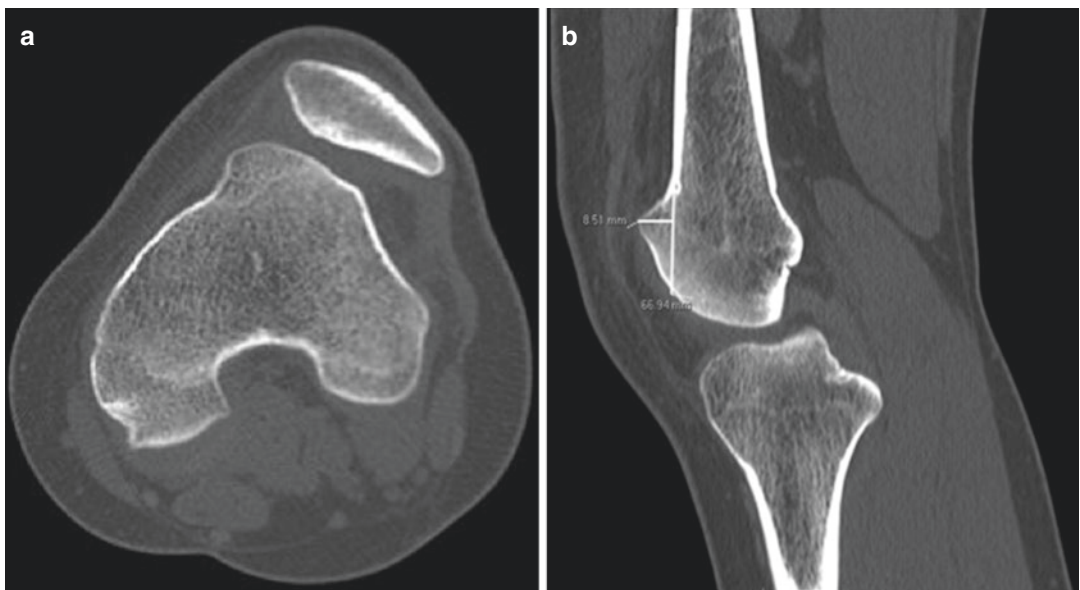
Sagittal and axial CT scan views of a large supratrochlear spur measuring 8.51 mm relative to the anterior border of the femur
